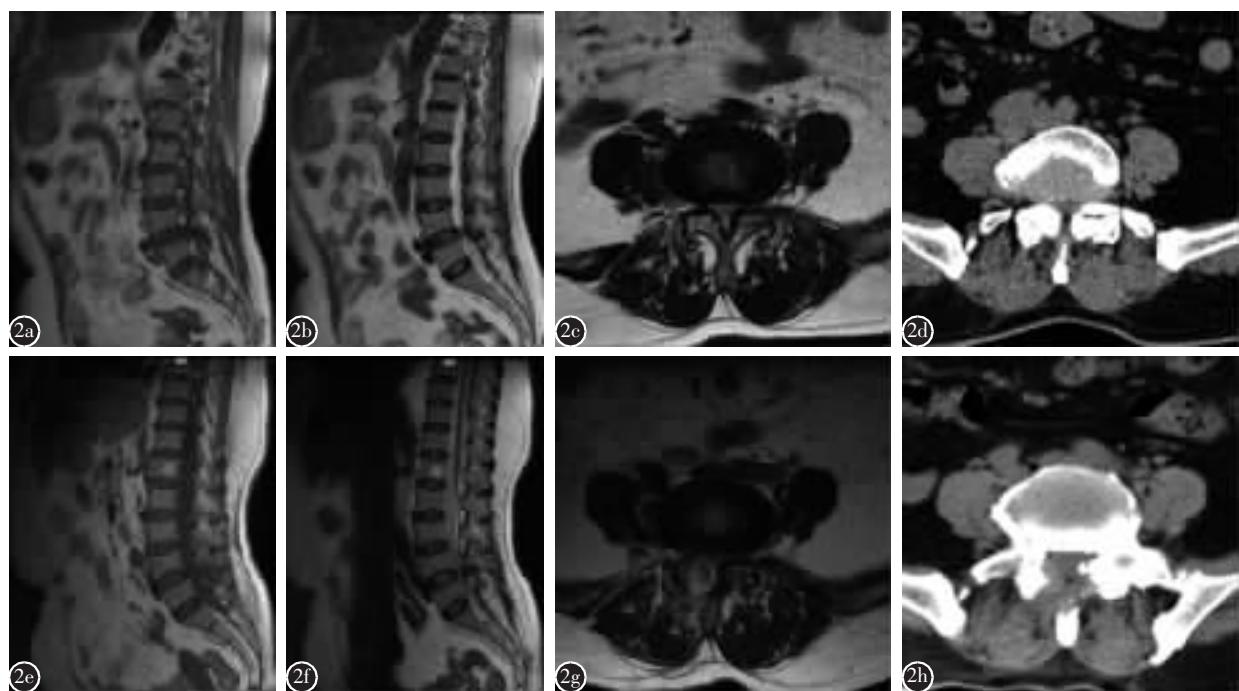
患者女,60岁 a~c 术前 MRI 示 L4~5 双侧黄韧带增厚, 腰椎管狭窄 d 术前 CT 示 L4~5 椎管狭窄 e~g 术后 1 周 MRI 示 L4~5 硬膜囊及双侧神经根压迫解除 h 术后 1 周 CT 示 L4~5 双侧椎板部分切除, 椎管减压充分
